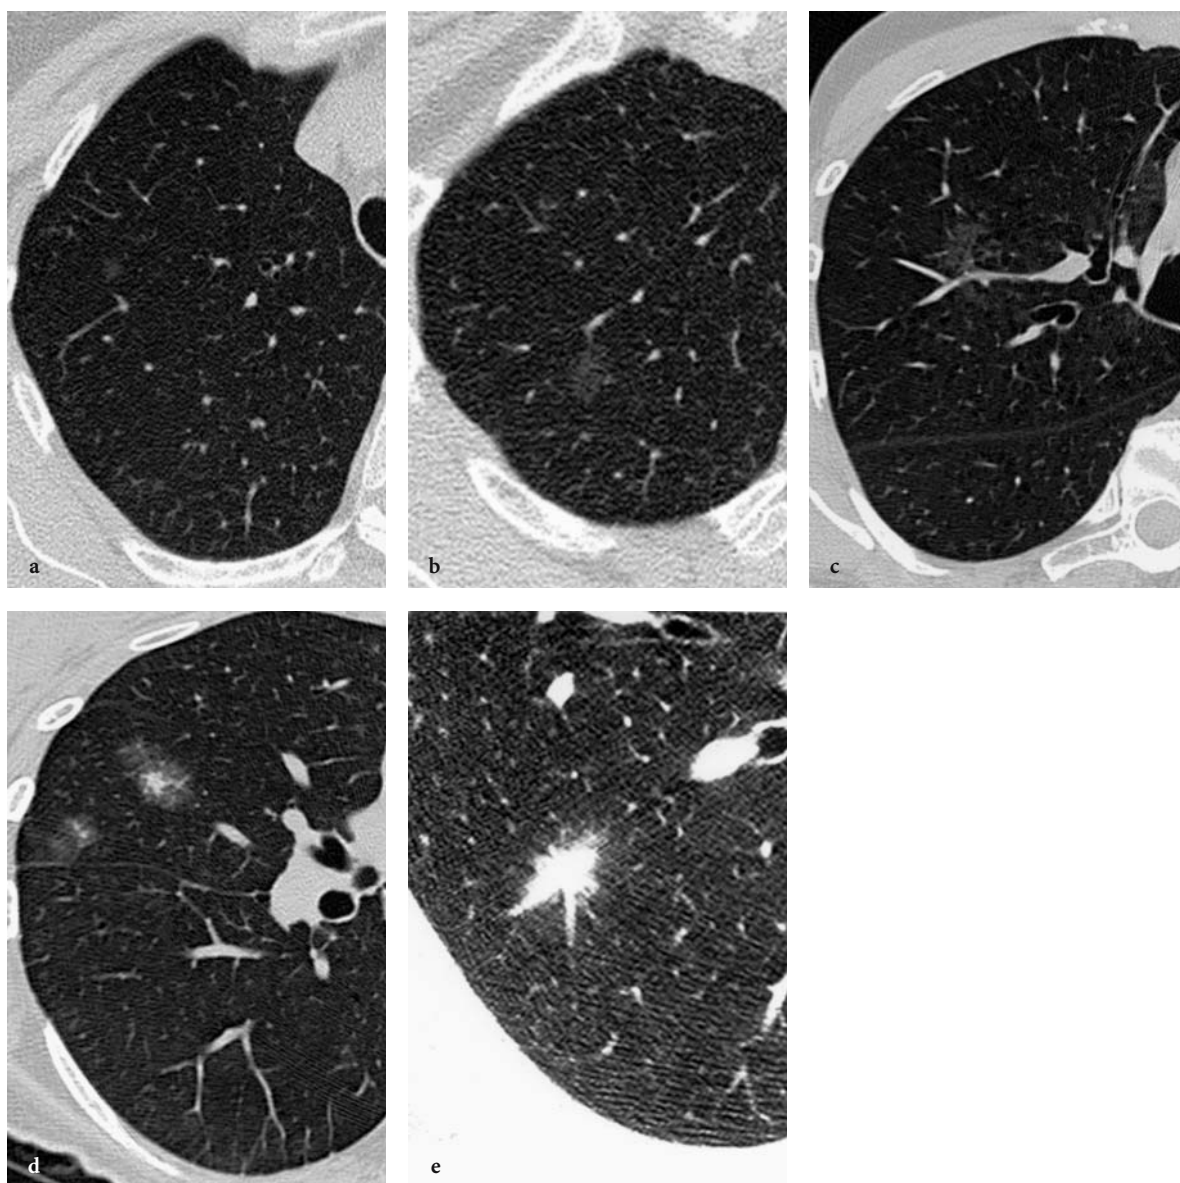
Adenocarcinoma of the lung: CT appearances. a, b One-millimeter target reconstructions through the right upper lobe in two separate patients, respectively show characteristic appearance of well defined pure ground glass nodules. The smallest of these is consistent with an incidental focus of atypical adenomatous hyperplasia while the larger raises the possibility of an early bronchoalveolar cell carcinoma, corresponding to Noguchi type A adenocarcinoma (localized bronchoalveolar cell carcinoma). c 1 mm target reconstruction through the right upper lobe in a different patient than shown in a, b. A poorly defined ground glass nodule is identifiable in the mid portion of the lung. This appearance corresponds to Noguchi type B adenocarcinoma. d One-millimeter target reconstruction through the middle lobe in a different patient than shown in a–c. There are two separate sub-solid nodules present both with clearly definable solid components. This appearance corresponds with Noguchi type C adenocarcinoma in this case in a patient with documented multifocal bronchoalveolar cell carcinomas. e One-millimeter target reconstruction through the right lower lobe in a different patient than shown in a–d. In this case there is a spiculated predominantly solid nodule surrounded by faint ground glass attenuation. This appearance corresponds with Noguchi types D–F invasive adenocarcinoma, subsequently verified surgically
